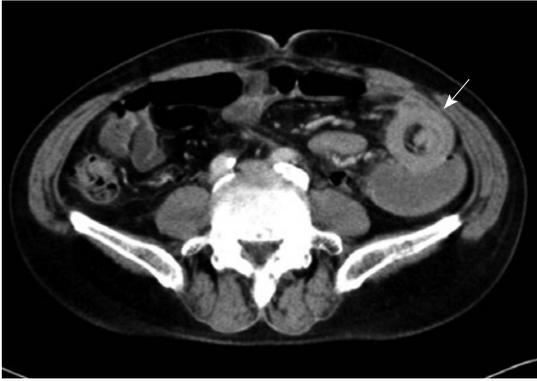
Abdominal computed tomography discloses a typical “target sign” over the small intestine (arrow).
